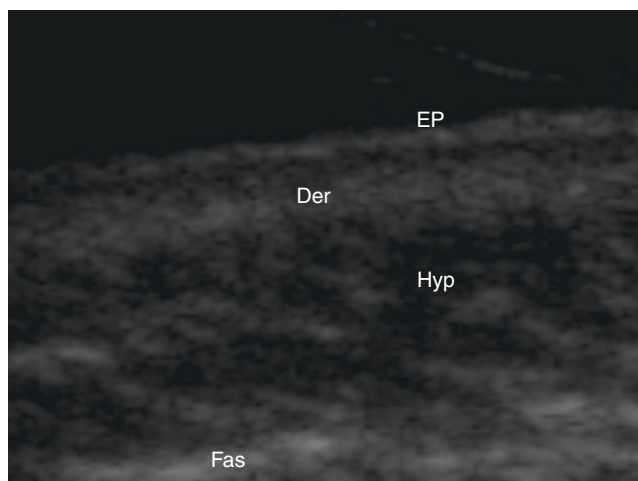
Structure of normal skin as seen on ultrasound. EP indicates epidermis; Der, dermis; Hyp, subcutaneous tissue; Fas, fascia.
